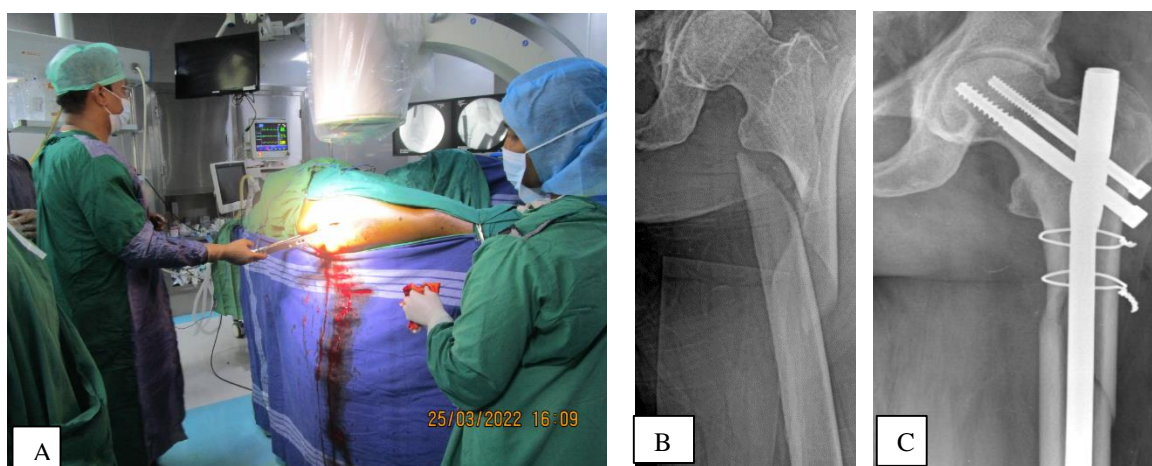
A) Showing intra operative image during the procedure, B) Showing preoperative radiography of the same patient, C) Showing post operative radiology where cephalomedullary nailing with cerclage wiring was done
